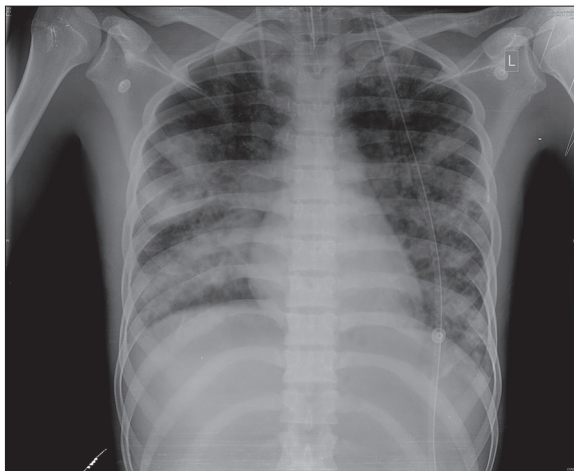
Chest X-ray showing alveolar shadows
